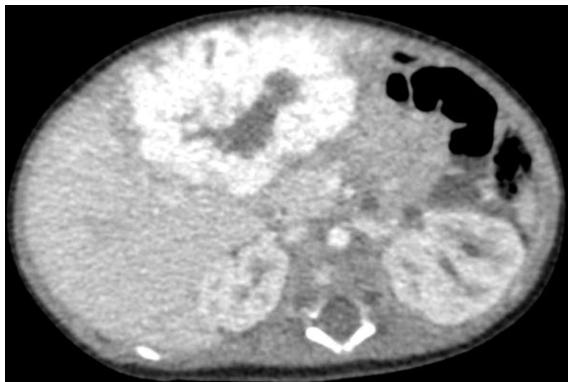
Abdominal computed tomography-contrast. Focal hepatic hemangioma that shows centripetal enhancement and central sparing because of thrombosis, necrosis and/or intralesional hemorrhage.
